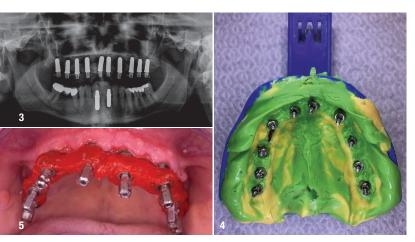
Panoramic radiograph post-op. Fig.4: Closed-tray impression post-op. Fig.5: Post-op situation with healing abutments and platelet-rich fibrin mixed with bone grafting material draped around the implants and abutments.
